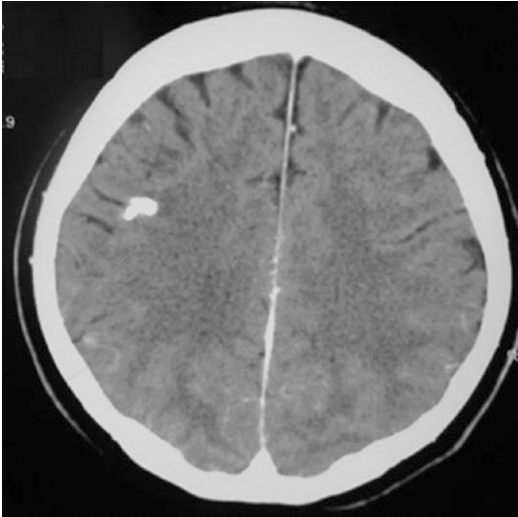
Treated tuberculoma. Axial CT image in a patient with history of treated TB shows a calcified lesion in *right* frontal lobe without edema or mass effect
